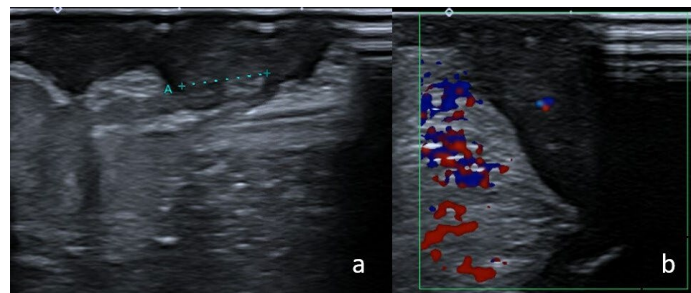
Testicular Doppler Ultrasound at a four-month follow-up. a) The left testis size was 7.4 mm, but homogenous, and the b) Doppler flow was weak.
